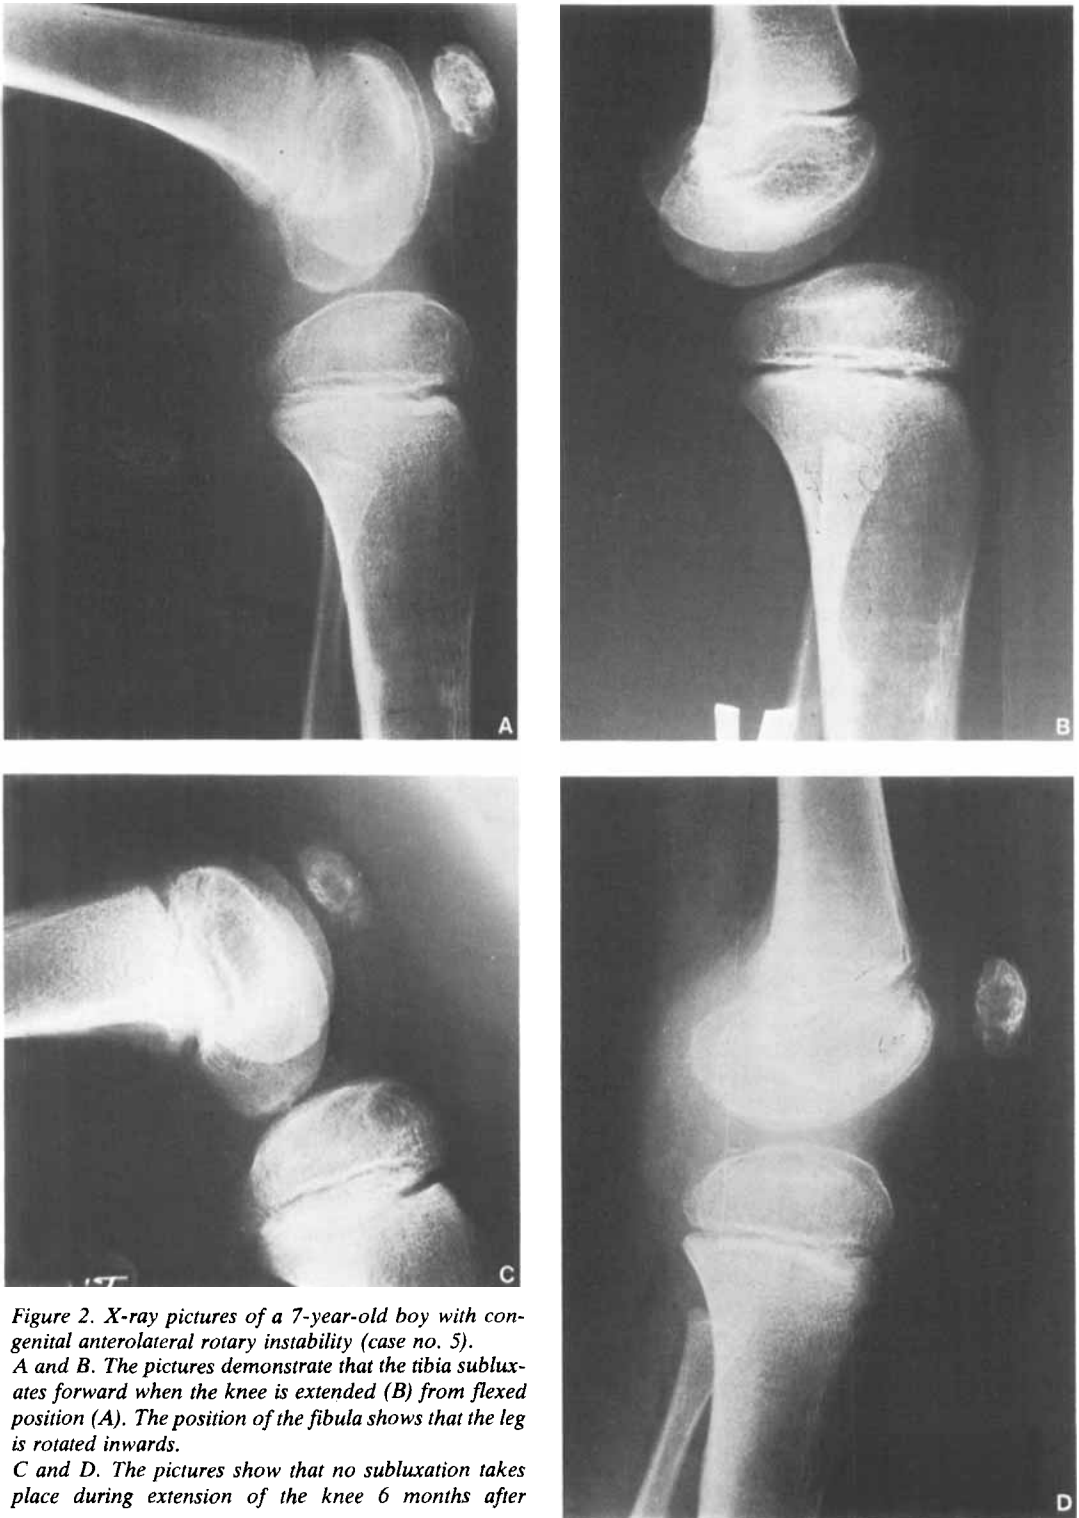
X-ray pictures of a 7-year-old boy with congenital anterolateral rotary instability (case no. 5). A and B. The pictures demonstrate that the tibia subluxates forward when the knee is extended (B) from flexed position (A). The position of the fibula shows that the leg is rotated inwards. C and D. The pictures show that no subluxation takes place during extension of the knee 6 months after surgery.
